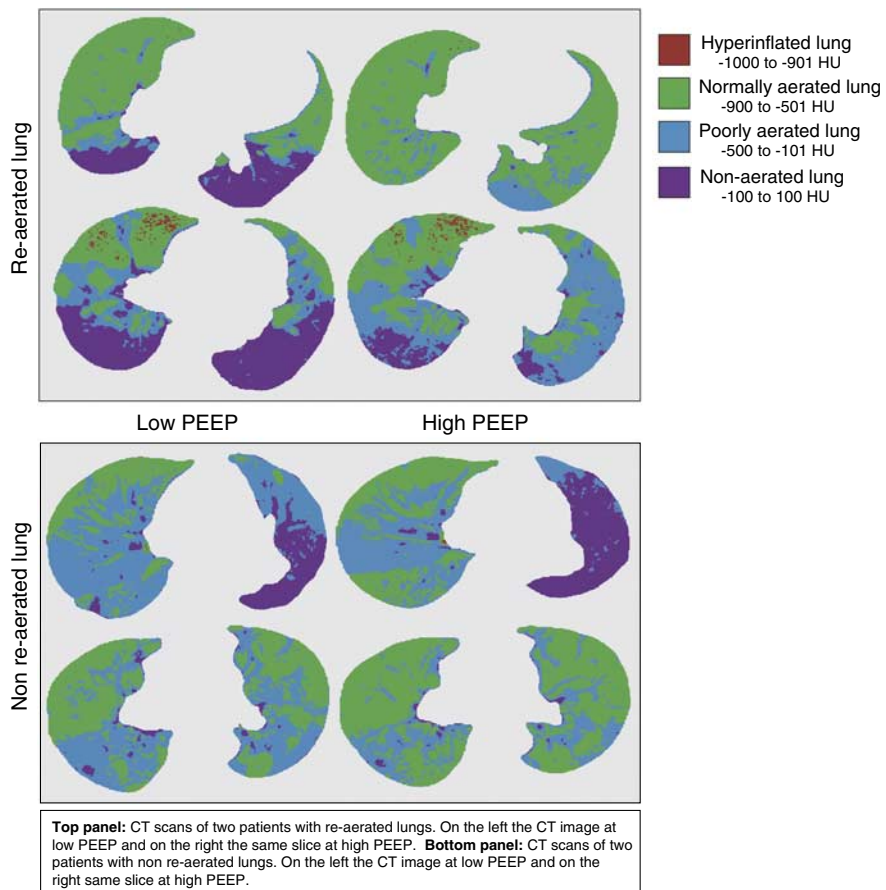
Overview of CT scans of re-aerated and nonre-aerated lungs.
